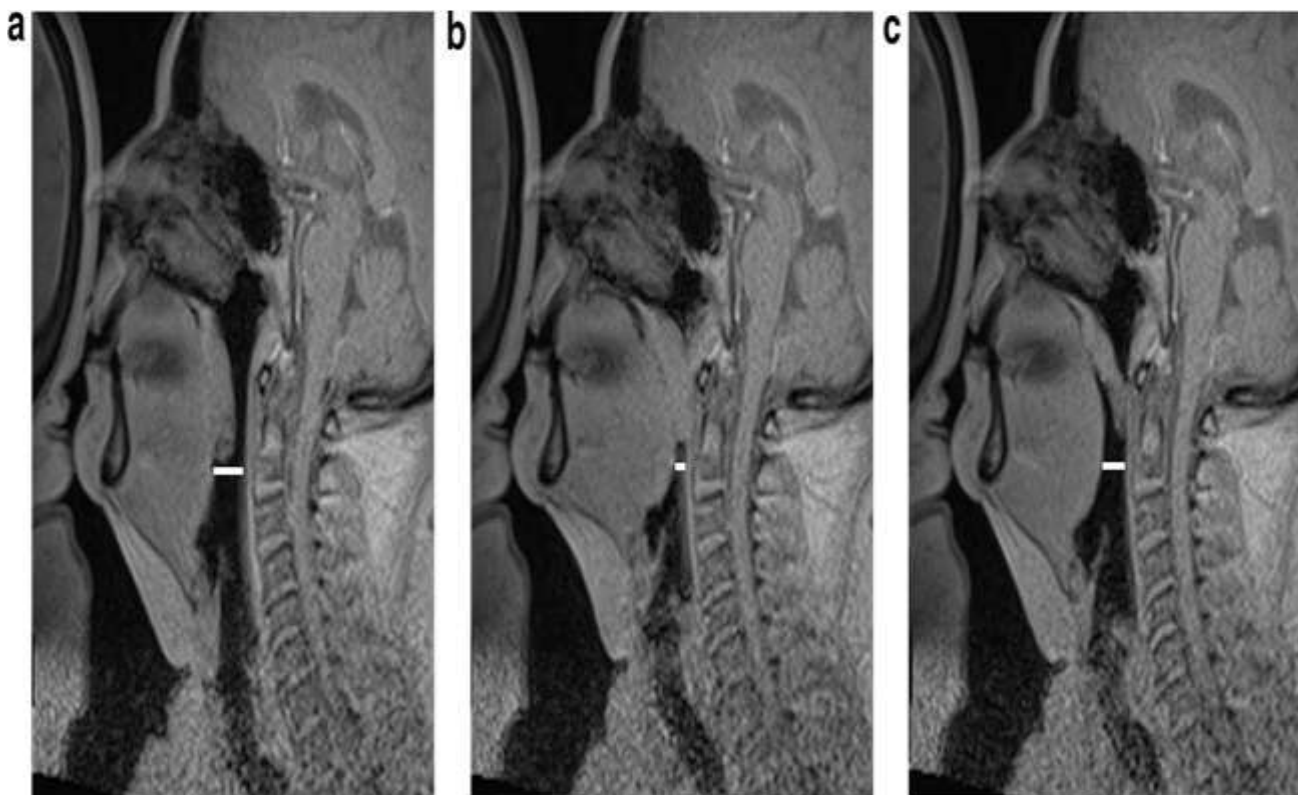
Midline sagittal magnetic resonance images showing two types of complete airway obstruction: open airway (A), obstruction with soft palate attached (B) or detached (C) to the tongue base. Note the significant narrowing of the retrolingual space in the first type and no narrowing in the second type of obstruction (white line). (25)
